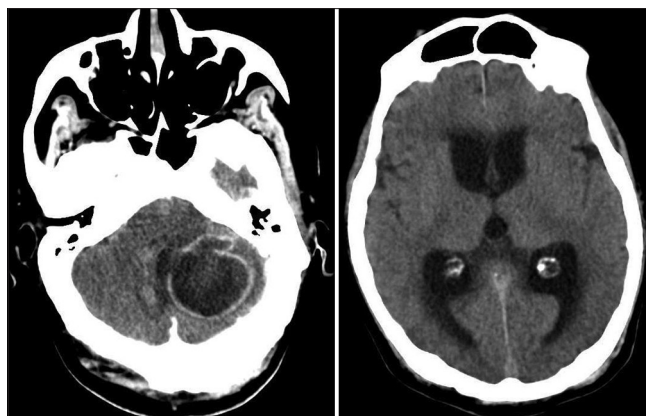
Contrast-enhanced head computed tomography showing large cerebellar mass with fourth ventricle and brainstem compression (left) and triventricular hydrocephalus (right)
